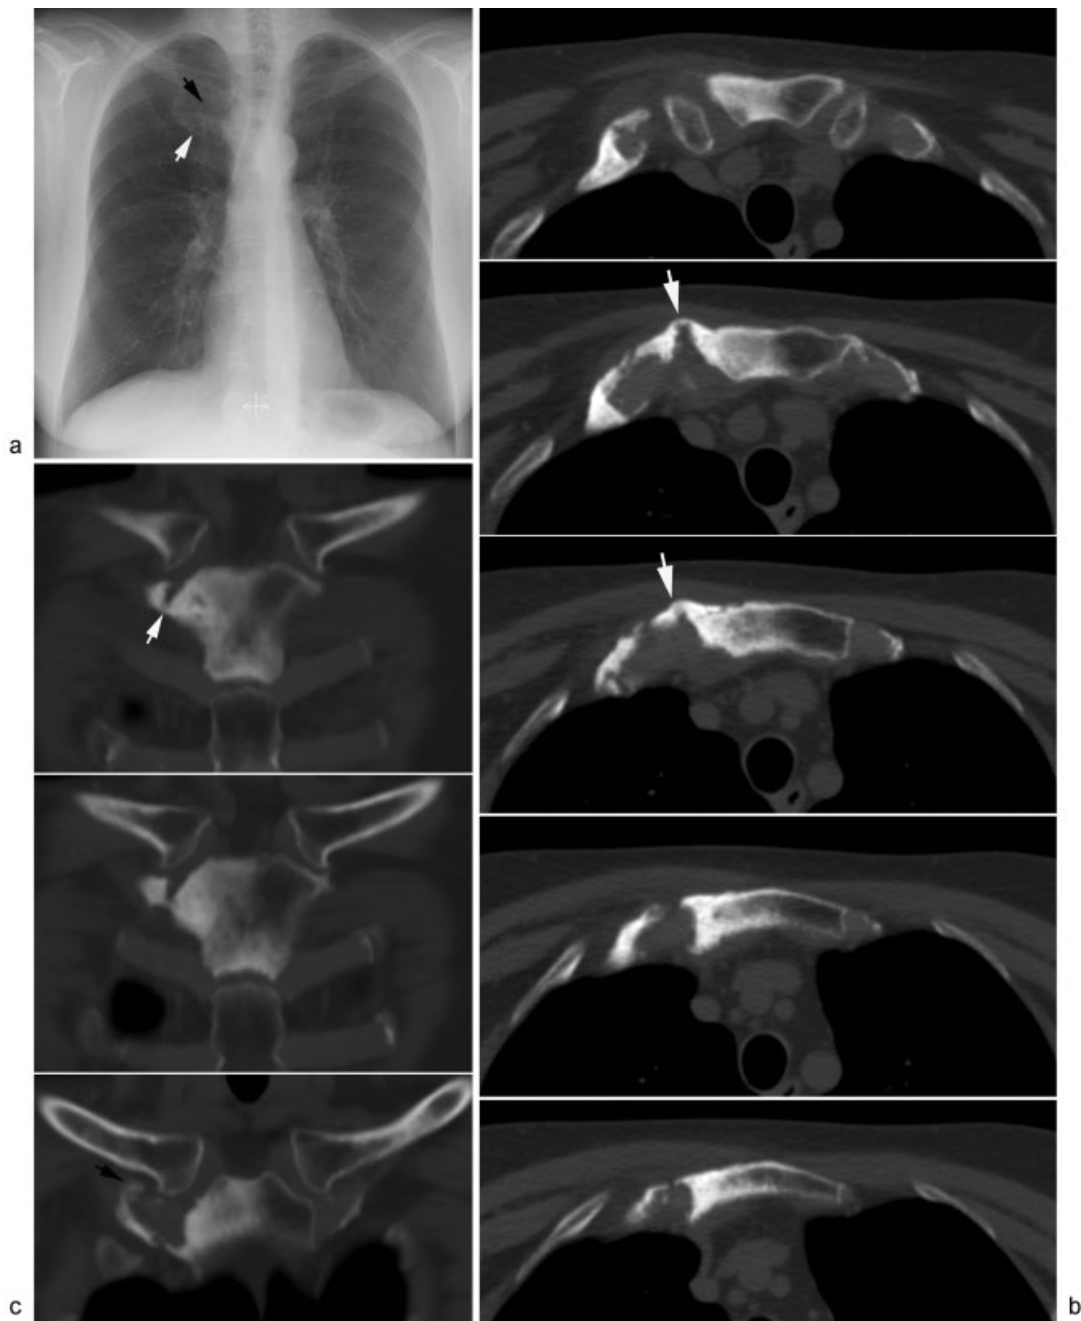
Anterior chest wall involvement in adults. A 63-year-old woman with pustulosis palmoplantaris (PPP) and recurrent pain and swelling in the sternoclavicular region for several years. (a) Chest radiograph showing condensation in the region of the right sternoclavicular and first sternocostal joint with certain mineralization/ossification located at the first costal cartilage (white arrow) and possible ossification at the right costoclavicular ligament (black arrow). (b) Computed tomography (CT): axial slices from the upper to the lower part of the manubrium and (c) coronal reconstructions from anterior to posterior. There is osseous sclerosis corresponding in the right side of the manubrium sterni extending to the manubriosternal joint where there is an uneven joint facet, but the sternal body is normal. There is no involvement of the clavicles, except osteophyte formation, but there is osseous irregularity corresponding to the first right sternocostal joint and hyperostosis of the costal cartilage with a border of homogeneous mineralization including a sclerotic bridge anteriorly (white arrows) and also a slight ossification of the costoclavicular ligament (black arrow). (d) MRI of the region as part of whole-body MRI, coronal slices from anteriorly to posteriorly, short tau inversion recovery to the left and T1-weighted images to the right, shows osseous edema corresponding to the manubrium sterni with concomitant edema at the first costochondral junction and the surrounding soft tissue (arrows). Late changes in a 72-year-old woman with PPP and left-sided shoulder pain accompanied by restricted movement for 11 years. (e) Chest radiograph shows an ossified mass between the left clavicle and the costal cartilage (arrows). (f) CT, coronal reconstruction, and (g) three-dimensional reconstructions show pronounced ossification corresponding to the left costoclavicular ligament in addition to partial ankyloses of the sternoclavicular joint.
